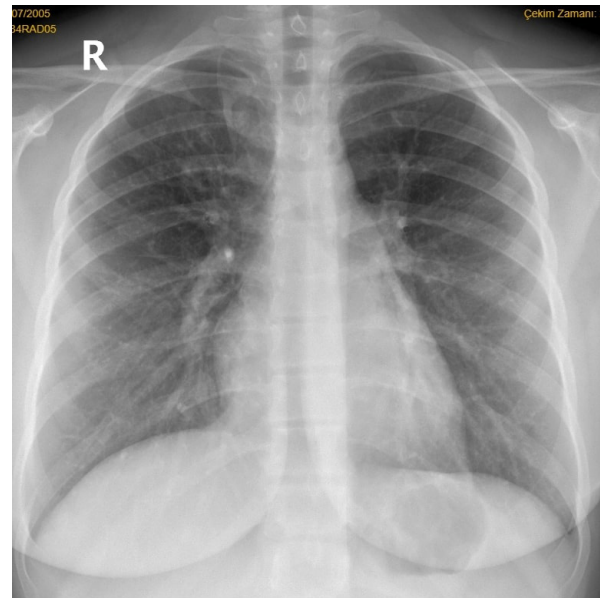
Abnormal chest X-ray image with bronchial wall thickening
